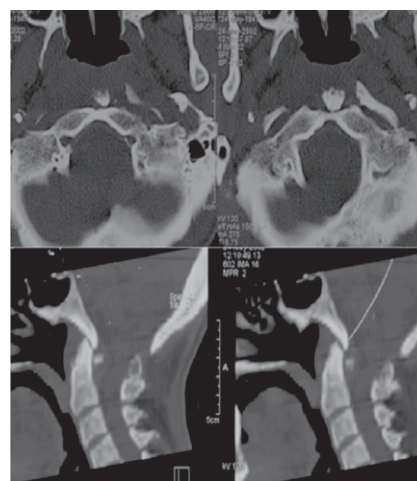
CT of the CV-Junction of case 1 showing fracture of the posterior arch of C1 with right occipital condyle fracture, and a type 3 Atlanto occipital dislocation.
